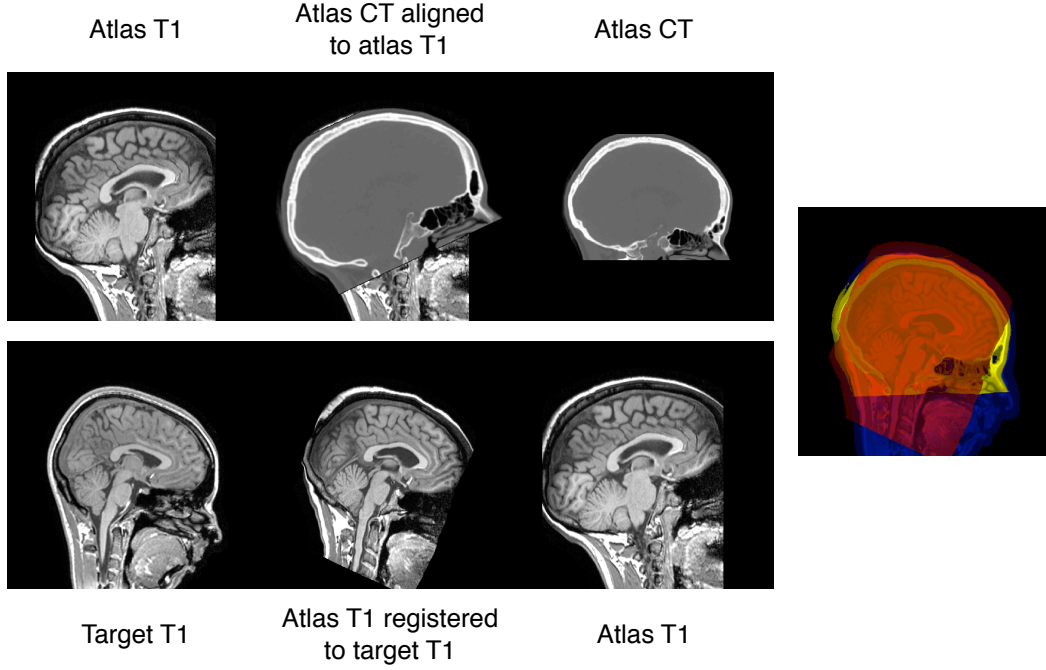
Left: Both the intra-subject CT to MRI mapping (top) and inter-subject MRI to MRI mapping (bottom) can lead to mismatching information. Right: The fusion must be restricted to the area where the target T1 (blue), the atlas T1 (red) and atlas CT (yellow) coincide.
